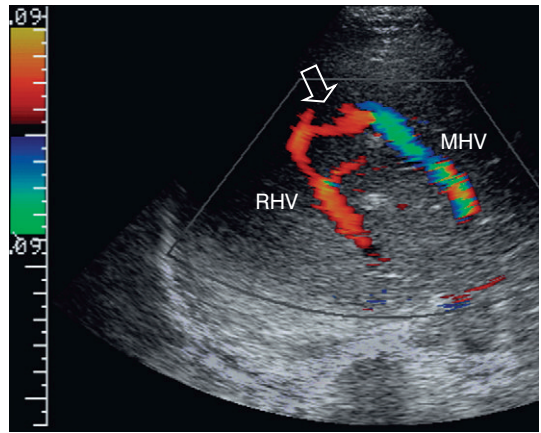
Transverse colour Doppler view of the mid-liver in a patient with catheter related inferior vena cava thrombus. Flow in the right hepatic vein (RHV) is reversed and coursing towards the transducer. A prominent collateral vein (arrow) then carries flow to the middle hepatic vein (MHV) and back towards the heart. Note the aliasing the more distal hepatic vein due to the higher velocity caused by the increased volume of flow.
